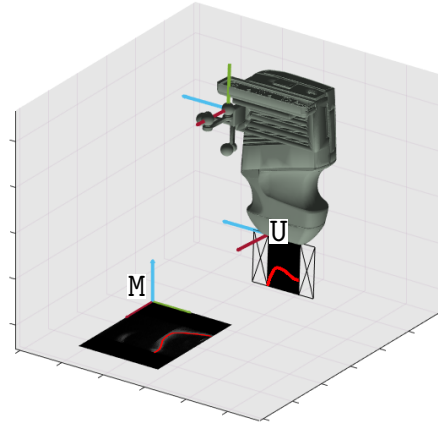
Ultrasound images collected through the Clarius API are in a size of  $640 \times 480$ . The origin of the ultrasound image frame M was defined as pixel (0,0). A fixed, known transformation from M into the ultrasound scanner’s frame U was applied to all segmented pixels to project them into 3D points. Finally, the 3D points in U were transformed into the global coordinate system using the selected odometry source.
